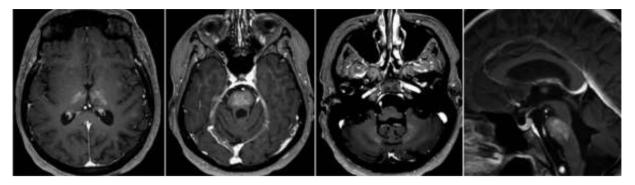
Post-gadolinium axial and sagittal T1w images at different representative levels, performed at diagnosis. MRI examination showed punctate symmetrical contrast-enhancement within basal ganglia and pons, extending to adjacent midbrain and middle cerebellar peduncles, as well as to the medial aspects of cerebellar hemispheres.
